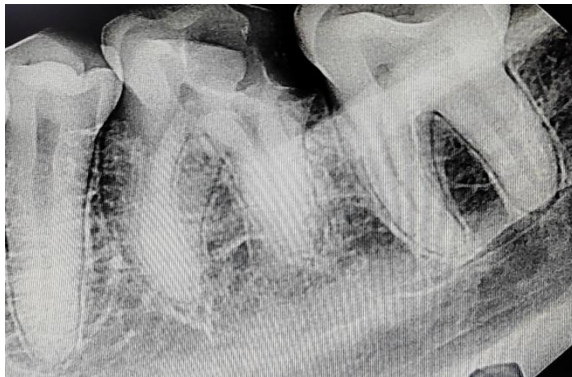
Radiographic image depicting presence of two distal roots
